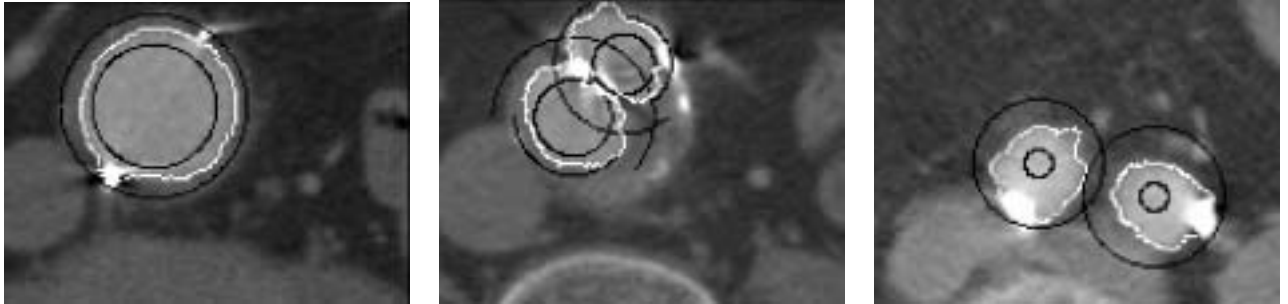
Example CTA slices showing the boundaries of the polar plot (black) and the contours detected (white) for, from left to right: the proximal part of the graft; just above the bifurcation; and the distal graft part.
